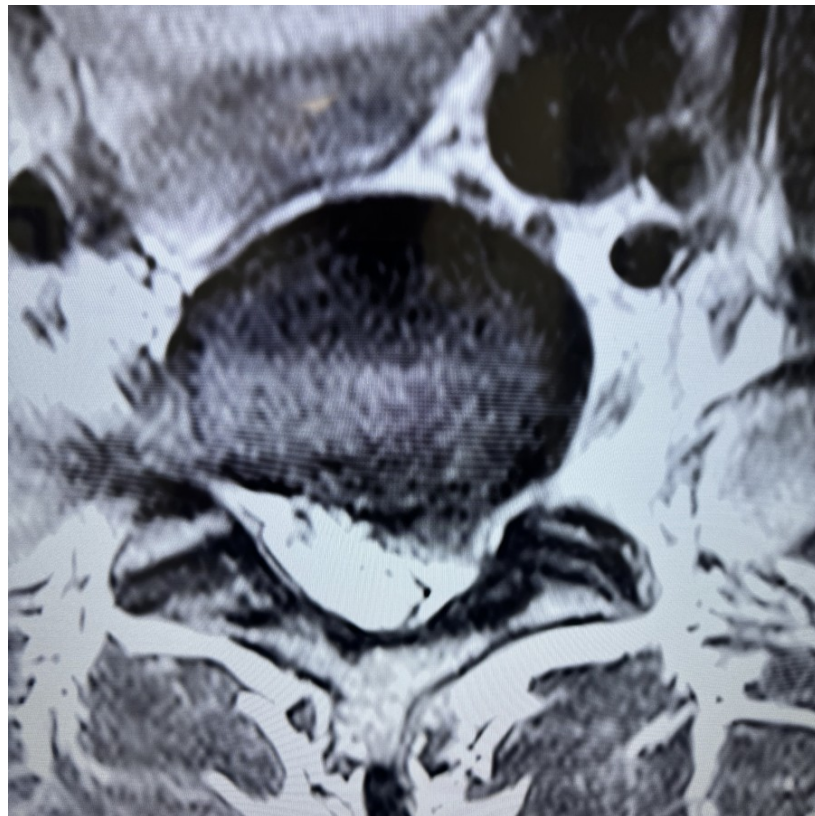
Post-treatment axial MRI image at the L5-S1 intervertebral disc level demonstrating reduction in disc protrusion size following 18 days of accelerated nonsurgical spinal decompression therapy. Reduced posterior disc protrusion and improved visualisation of the spinal canal are noted compared to Figure 1.
